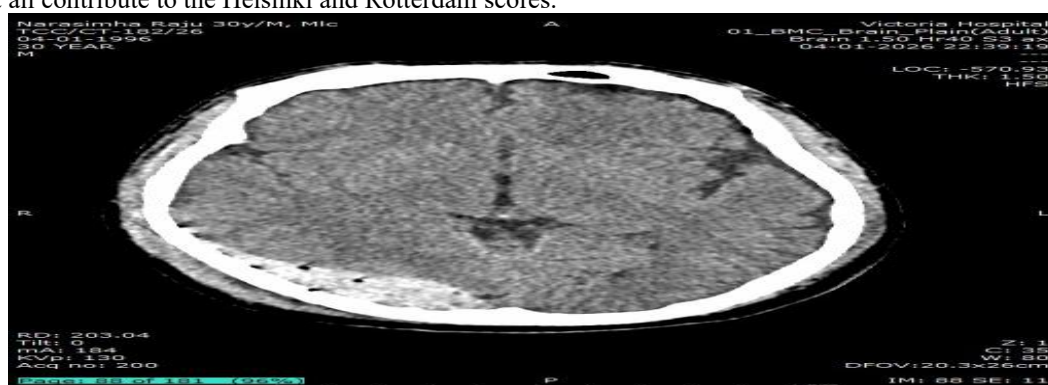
Axial NCCT of the head in a study patient showing an acute extradural haematoma in the right parieto-occipital convexity, measuring ~19.5 mm in maximum thickness, with mild mass effect (effacement of adjacent sulcal spaces). Epidural mass lesions are specifically weighted in both CT scoring systems.
